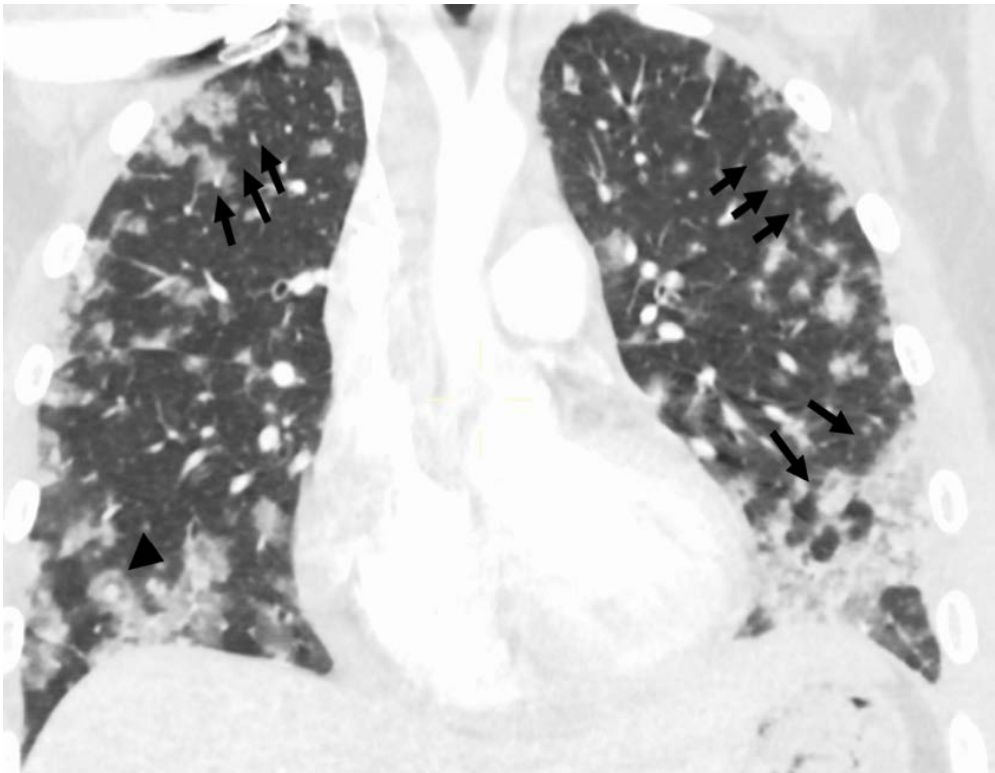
An axial CT scan with lung window settings of a male patient with cardiac angiosarcoma with lung metastasis, revealing several soft-tissue density nodules bilaterally (arrows), some of which being surrounded by a halo of ground-glass opacity (arrowhead).
